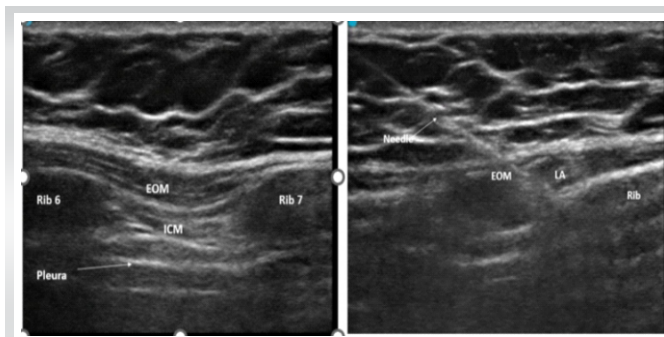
The ultrasonography picture of external oblique intercostal plane block. EOM- External Oblique Muscle, ICM- Intercostal muscles, LA- Local Anaesthetic
